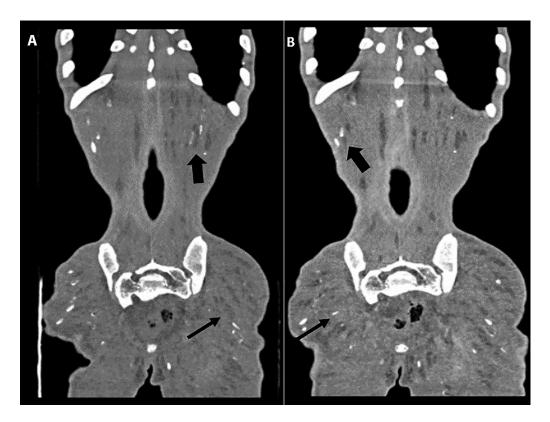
Coronal CT images showing multiple calcified and noncalcified granulomas in bilateral paraspinal muscles (black boxed arrows) and gluteal muscles (black arrows).
